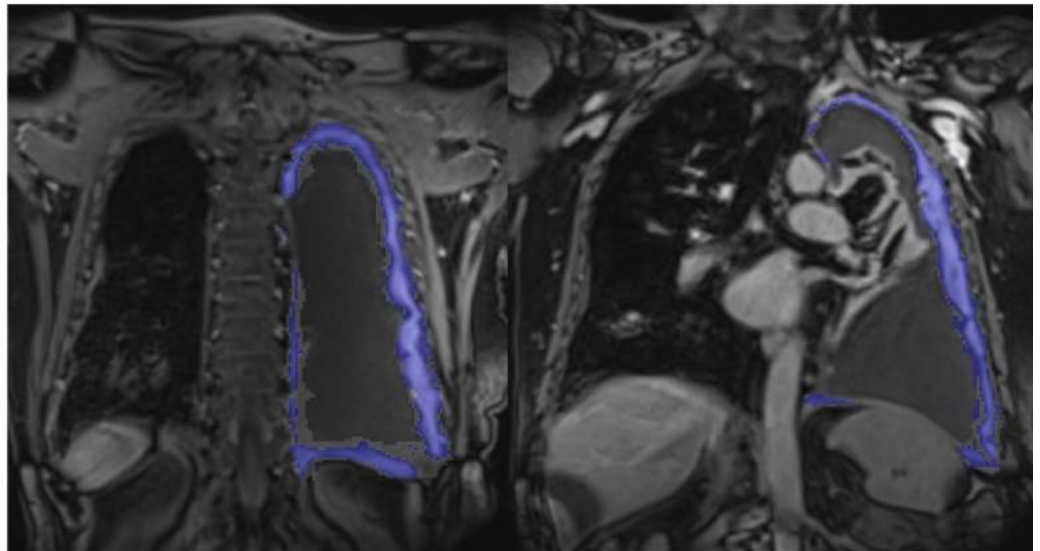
Semi-automated, threshold-based segmentation of pleural volume at contrast-enhanced MRI using Methodology 1 (SI of pleural ROI \pm 81AU). The segmented volume is highlighted in blue (Panels A (axial plane) and B (coronal plane)). Panel C is a 2D image of the completed volumetric study from anterior, left lateral and posterior positions.
